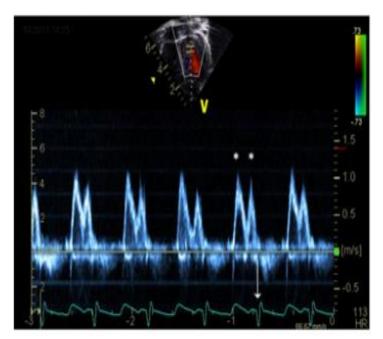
Atrio-ventricular dyssynchrony by mitral inflow doppler. Atrioventricular synchrony is optimal when distinct E and A waves are seen (asterisks) and the A wave terminates concurrent with the QRS complex (arrow) and not prematurely due to ventricular contraction.
